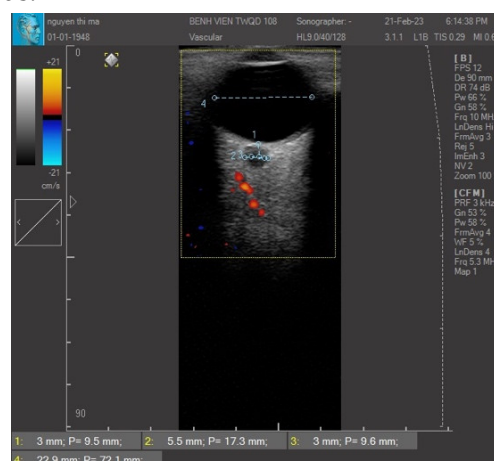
Ultrasound image of optic nerve sheath. 1: 3mm; 2: ONSD 5.5mm; 3: ONSD 3mm; 4: eyeball diameter 22.9mm.
